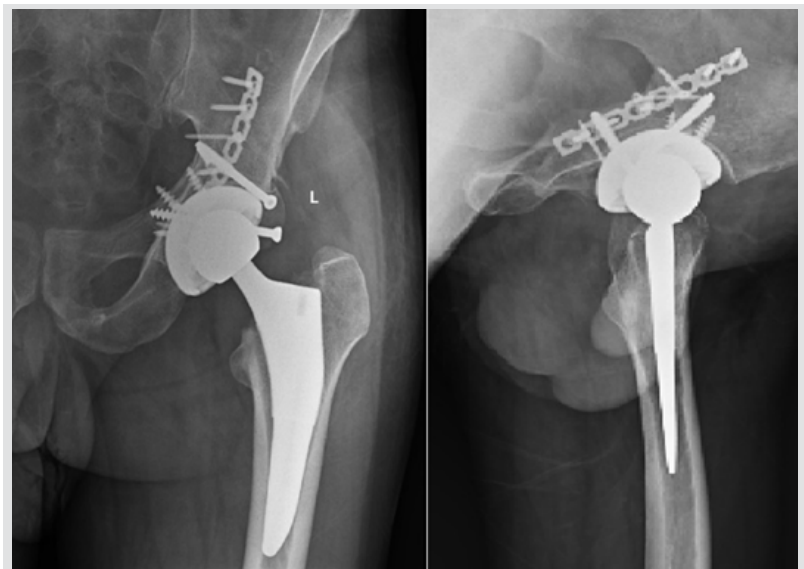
Final radiographs at 2-year follow-up showing stable well-fixed implant without any signs of loosening or osteolysis.
